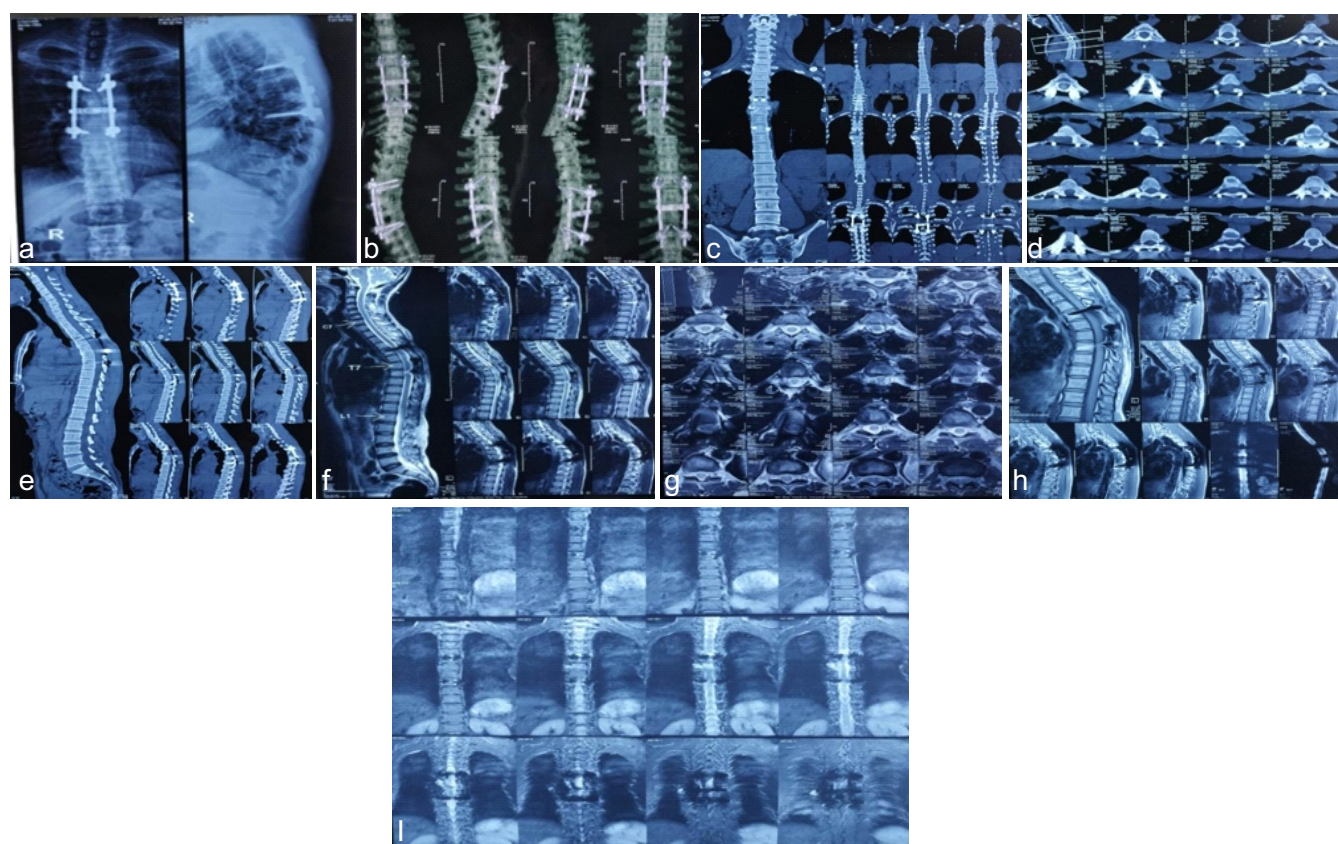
Postoperative findings at 4-year follow-up (a) AP and lateral radiographs and (b) 3D Reconstruction CT of Dorsal spine demonstrated satisfactory posterior pedicle screw-rod fixation across the involved thoracic vertebrae with a transverse cross-link connector. The implants were appropriately positioned with maintained spinal alignment and no radiographic evidence of implant loosening, pull-out, breakage, or loss of correction. (c,d,e) CT Scan show stable posterior instrumentation from D5 to D8 with satisfactory alignment. Mild multilevel spondylotic changes were noted, while vertebral body heights, spinal canal, and neural foramina were preserved. (f,g,h,i) MRI showed persistent D5–D8 spinal cord contusion with no significant cord compression and expected postoperative changes following D5–D8 posterior instrumentation. Mild multilevel degenerative changes were also noted.
